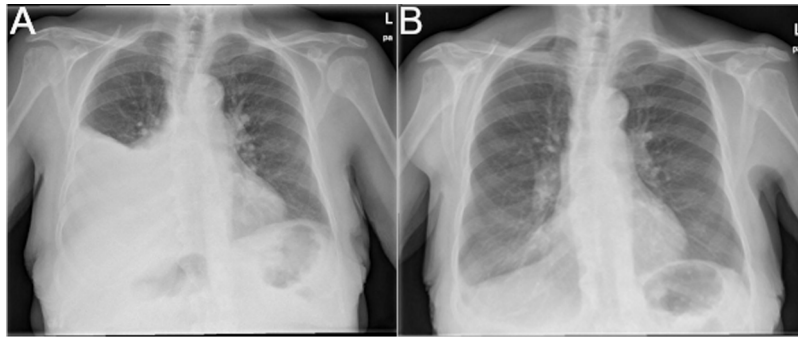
A) Posterior-anterior chest X-ray showing a right pleural effusion. B) Post-chemical pleurodesis posterior-anterior chest X-ray showing resolution of the pleural effusion.
